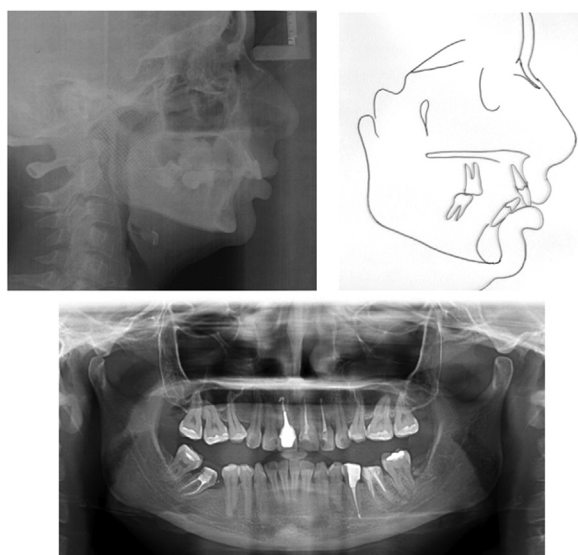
Patient 1. Pretreatment lateral cephalometric radiograph, tracing and panoramic radiograph.
